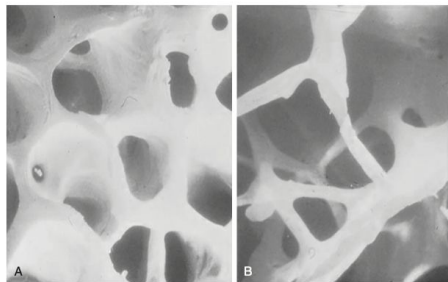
The appearance of normal bone (A) and bone with severe osteopenia (B) as seen on a dual-energy x-ray absorptiometry (DEXA) scan. Osteopenic bone is much more susceptible to fracture and deformity.
